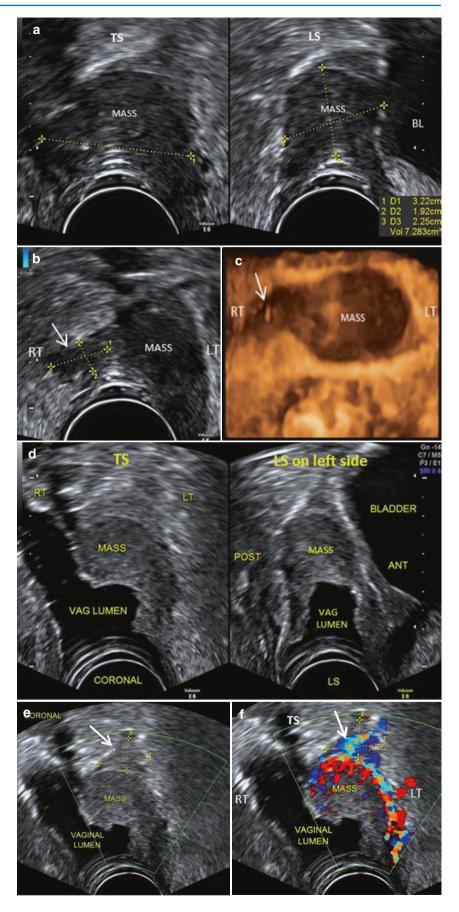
Primary vaginal carcinoma. Hysterectomy was done 18 years ago for menorrhagia. Patient presented with bleeding. (a–c) Regular TVS. (a) Showing hypoechoic mass in the upper vagina, (b, c) 2D and 3D images showing a hypoechoic narrow extension (*arrows*) onto the right side, raising a suspicion of right paravaginal infiltration. (d–f) GSV – mass seen involving the left side of the vagina. The right extension seen earlier on regular TVS was found to be the normal collapsed vagina on the right side, which, on being filled up with vaginal gel, displayed the normal vaginal walls. Supravaginal extension of the mass is seen on greyscale and on Doppler (*arrows*) in (e) and (f)
